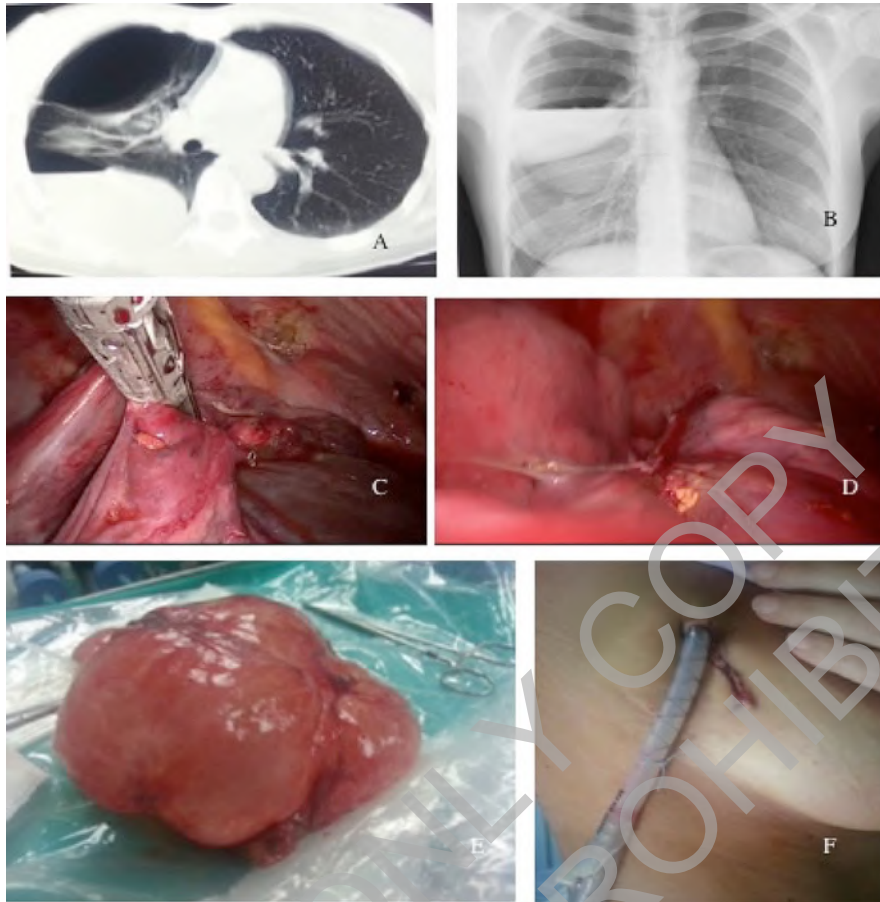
A) and B): CT scan and chest X-ray image of preoperative hydro-pneumothorax. C): Resection of giant bulla by articulate endostapler. D) Remaining lung parenchyma after resection. E) Inflated giant bulla after surgical removing (15 x 7 cm). F) 4-cm incision for uniportal access with 28ch chest tube.
